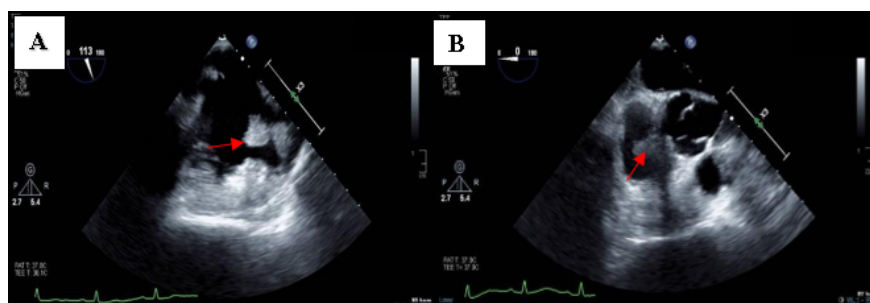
(A-C): Transesophageal echocardiography showing mobile mass in the right atrium in the bicaval (A) and short axis (B) views (arrows). Chest CT (C) showing the same mass in the right atrium (arrow). The mass is attached to the septal leaflet of the tricuspid valve. The differential diagnosis was between right sided atrial myxoma and fibroelastoma.
